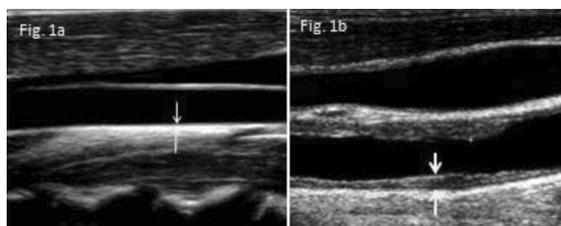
Ultrasonographic examination of carotid intima media thickness (distance between arrows) at the wall of the common carotid artery is shown: a) normal CIMT b) increased CIMT.
